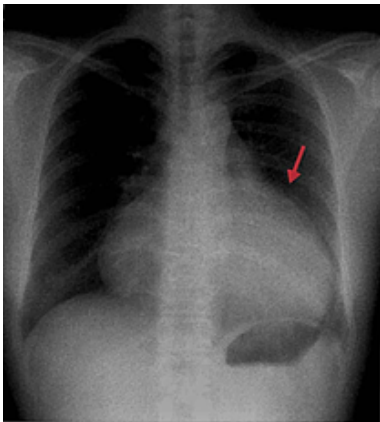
Chest Xray erect view showed cardiomegaly with Kerley B line
